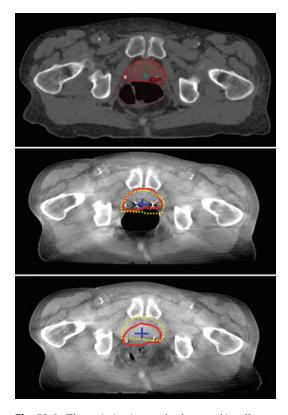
The variation in rectal volume and its effect on prostate location at the time of a single radiation treatment. At the time of radiation planning (top figure), the rectum is air-filled and the prostate (red) is located between the rectum and pubic symphysis. At separate times during the weeks of treatment, the rectal volume has changed shifting the prostate more posteriorly away from the symphysis (bottom figure). The prostate position at the time of radiation planning is depicted as a broken yellow line. When the rectal volume is significantly reduced compared to the planning CT, the prostate no longer resides within the preplanned target volume. Without appropriate shifting of the target, under-dosing of the posterior portion of the gland would occur as the target volume falls outside of or at the edge of the treatment field
